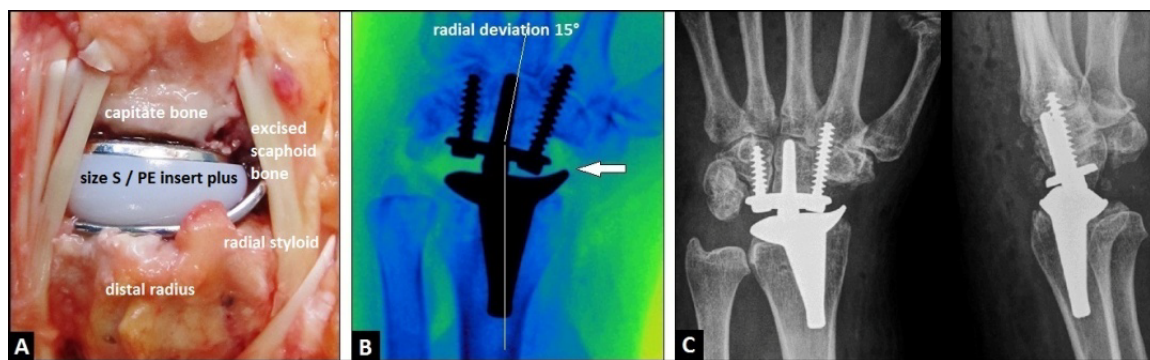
(A) Intraoperative photograph demonstrating uneventful insertion of the RE-MOTION™ TWA, the straight carpal plate size S has a sufficient bony support onto the capitae bone after excision of the entire scaphoid bone (B) Intraoperative fluoroscopy demonstrating that there was no impingement between the radial TWA component and the trapez bone at terminal range of radial deviation with 15° (arrow); (C) Postoperative PA and lateral radiographs demonstrating correct positioning of TWA. (PE: polyethylene).
